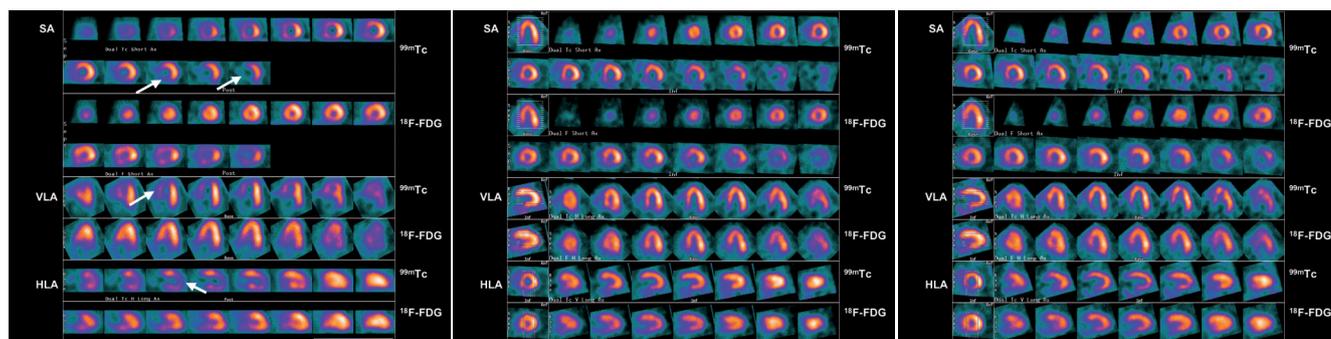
Example of dual isotope simultaneous acquisition $^{99\text{m}}\text{Tc}$ -sestamibi/ ^{18}F -FDG SPECT for assessment of myocardial viability. A. Pre-operative dual isotope simultaneous acquisition $^{99\text{m}}\text{Tc}$ -sestamibi/ ^{18}F -FDG SPECT in a patient with 3-vessel coronary artery disease and a left ventricular ejection fraction (LVEF) of 29%. From top to bottom: short-axis (SA), vertical long-axis (VLA), and horizontal long-axis (HLA) slices. There are extensive areas with perfusion/ metabolism mismatch indicating viable myocardium in the anteroseptal, posteroseptal, and apical regions (white arrows). B. Repeated $^{99\text{m}}\text{Tc}$ -sestamibi/ ^{18}F -FDG SPECT in the same patient one year after coronary bypass surgery. The perfusion defects substantially improved as compared to the pre-operative SPECT study, the LVEF improved to 36%. C. Repeated $^{99\text{m}}\text{Tc}$ -sestamibi/ ^{18}F -FDG SPECT in the same patient five years after coronary bypass surgery. The perfusion defects are comparable to the SPECT study at one year following revascularisation, the LVEF further improved to 45%.
